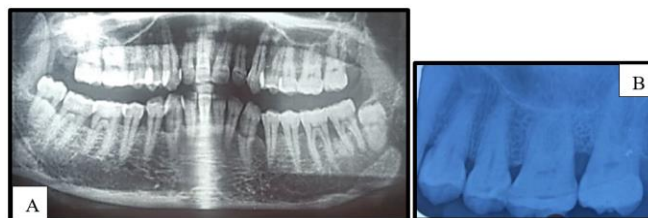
A): (OPG / Orthopantomogram) The red arrow points to an area of generalized horizontal bone loss around the molar region. In generalized horizontal bone loss, the alveolar crest is uniformly reduced in height, running parallel to the cemento-enamel junction (CEJ) but at a greater distance than normal (normally 1–2 mm). This pattern of bone loss is characteristic of generalized periodontitis rather than localized bone defects. Stage II → bone loss extending into the coronal third of the root (15–33%). Grade-A → slow rate of progression, no additional risk factors (like smoking or diabetes). B): (IOPA / Intraoral Periapical Radiograph) The red arrow shows horizontal bone loss between adjacent teeth. Alveolar crest appears flattened and lowered in relation to the CEJ. This confirms the localized manifestation of the generalized bone loss seen in the OPG.
